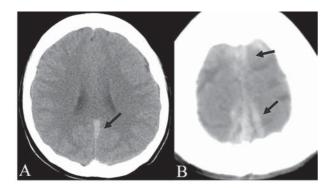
Unenhanced cranial CT scans disclosed cerebral venous thrombosis. (A) Abnormal high density was noted in part of the straight sinus (arrow). (B) The cord sign was demonstrated in the superior sagittal sinus and some cortical veins (arrow).
